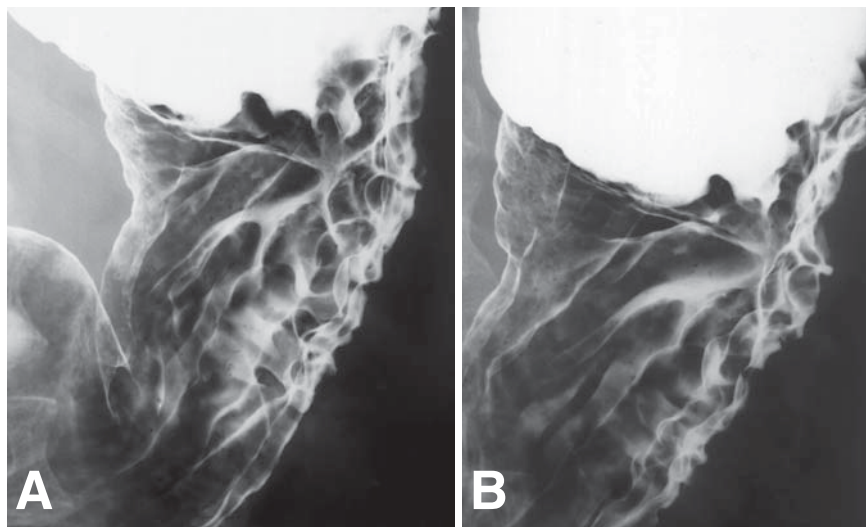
An ulcerative lesion with a gathering of folds on the posterior wall in the corpus of the stomach, demonstrated by upper gastrointestinal (GI) tract radiography examination
